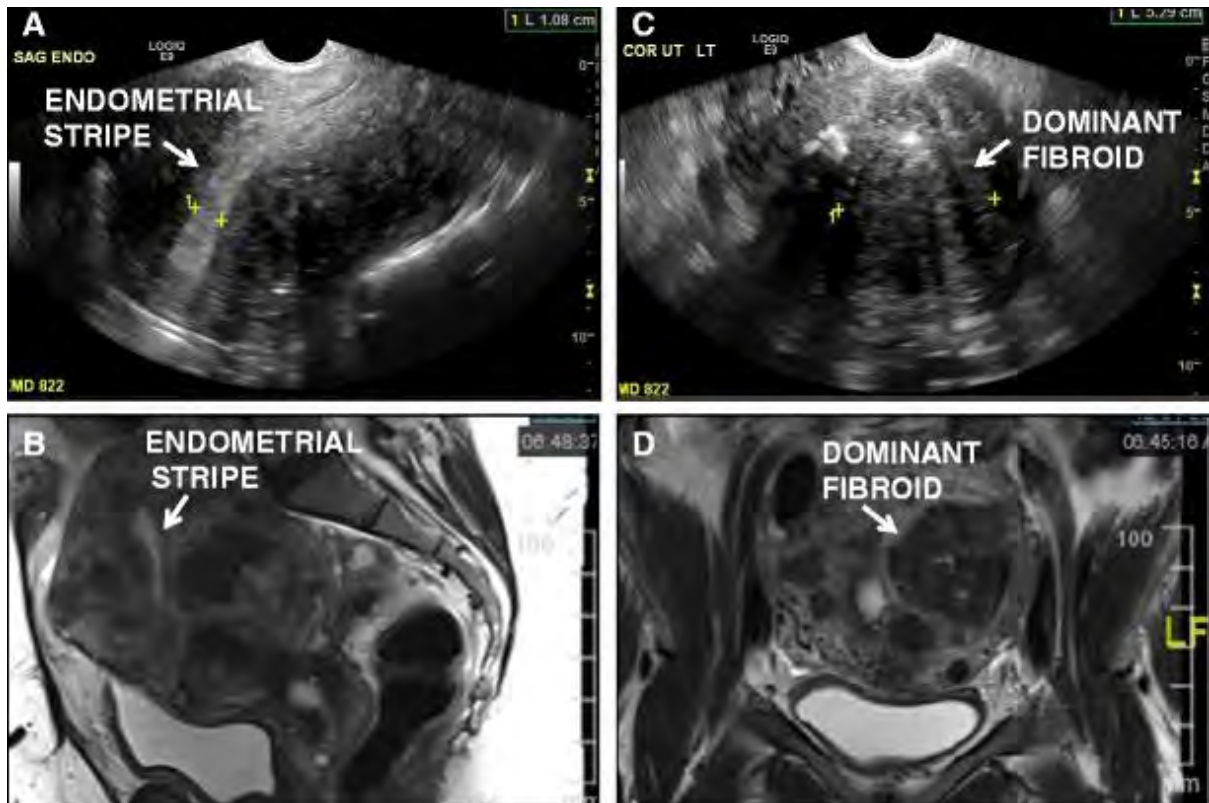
Comparison of ultrasound and MRI in the diagnosis of fibroids in the same patient. a Ultrasound with depiction of endometrial stripe. b MRI with depiction of the endometrial stripe and surrounding fibroids. c Ultrasound image of dominant fibroid. d Coronal view of MRI showing clear delineation of dominant fibroid as well as multiple other fibroids. (Foth, Römer, & Löffler, 2018)
